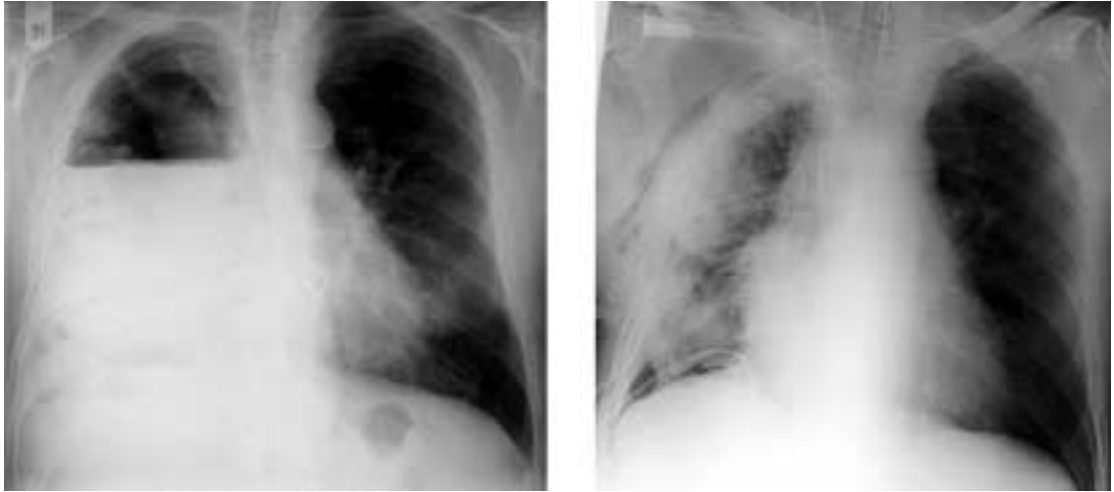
Chest X-ray in a patient with hemopneumothorax at the right side before (a) and after (b) thoracic surgery.
